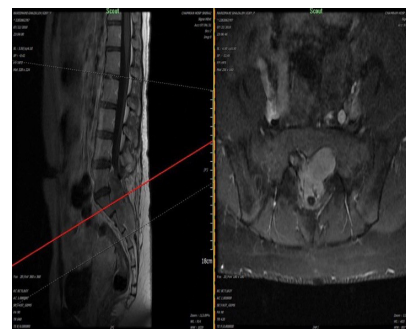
MRI of the lumbosacral vertebrae on the first tumor recurrence revealed hyposignal T1 in the spinal canal at the L5–S3 vertebrae level, isosignal in T2-weighted. The contrast-enhanced T1-weighted phase exhibited a homogeneous enhancement.
